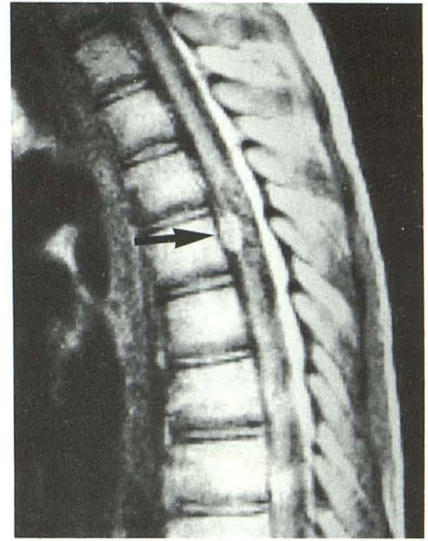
Thoracic intramedullary arteriovenous malformation in 15-year-old boy. Pre-midline hyperintensity on sagittal T1-weighted (400/28) image corresponds to a chronic subdural hematoma (arrow).
